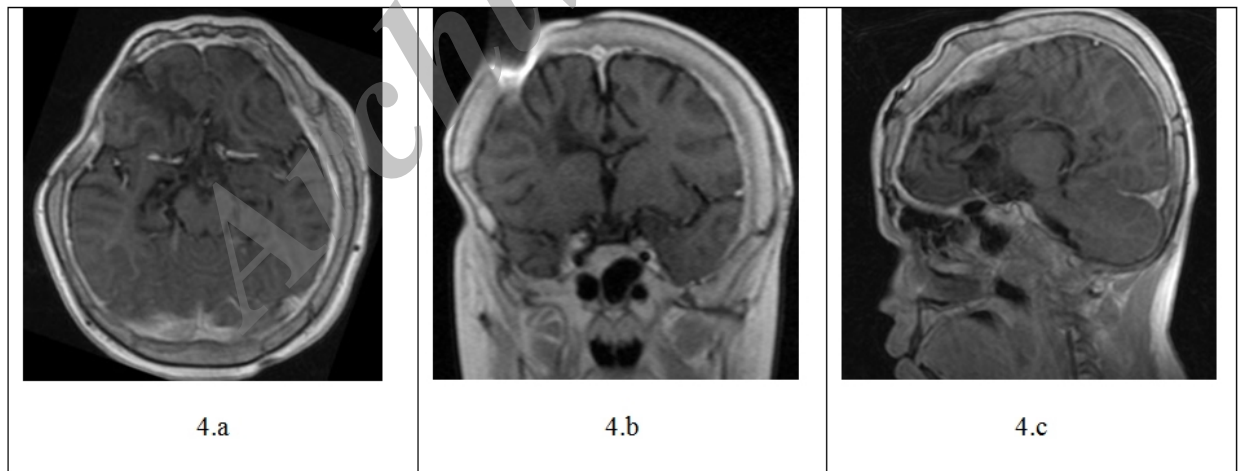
The follow up brain MRI with gadolinium injection, in axial(a), coronal(b) and sagittal views, showed no recurrence of the tumor
